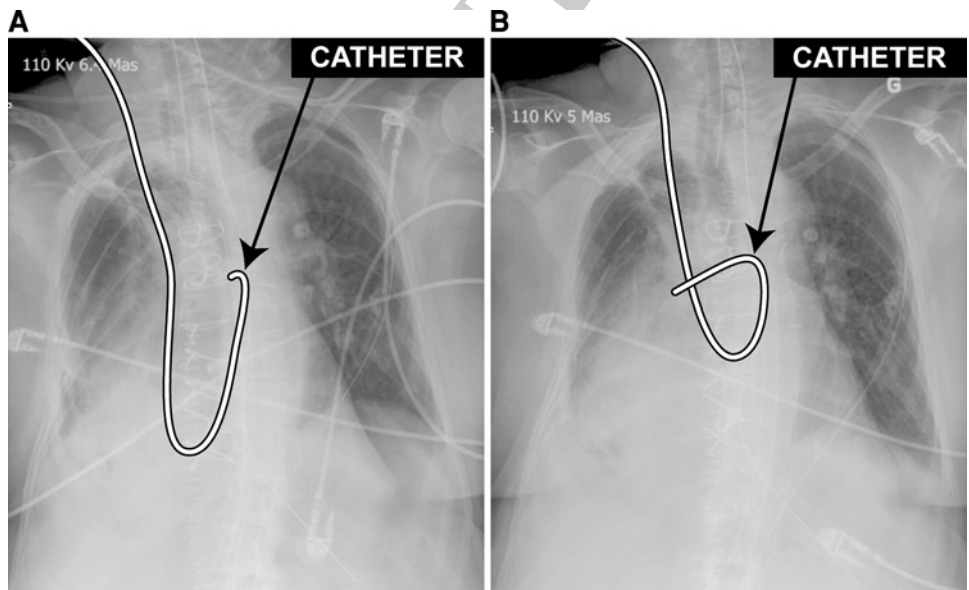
a Chest radiograph in a critically ill patient showing the normal position of the pulmonary artery catheter (line drawn on top of the catheter). b In regional cardiac tamponade, the catheter is
